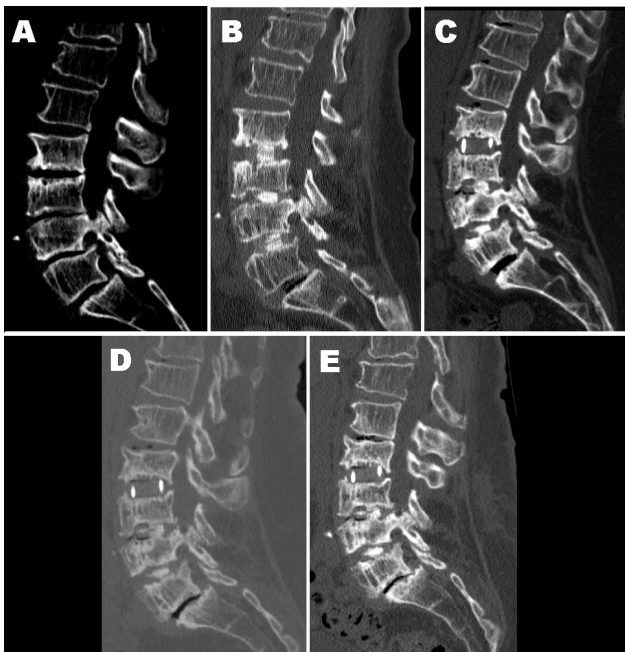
Sagittal CT scans pre-op (A), immediate post-op (B), 10 months after surgery (C), 26 months after surgery (D), and 36 months after surgery (E).
